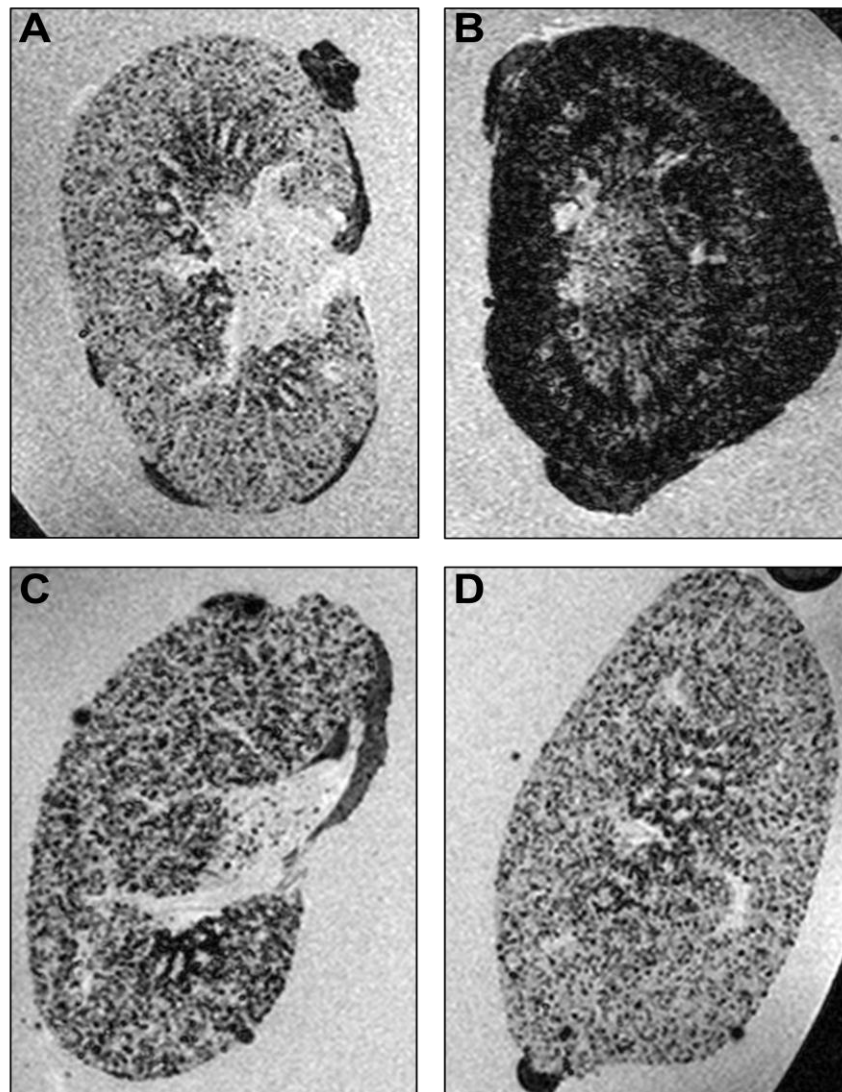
High-resolution *ex-vivo* MRI detects VCAM-MPIO in ischemic kidneys.
